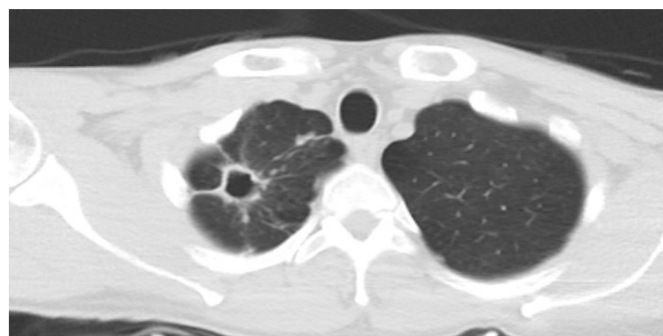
The figure represents a sample of a radiologic image of a "cavity" in a thoracic CT of an NTM patient
